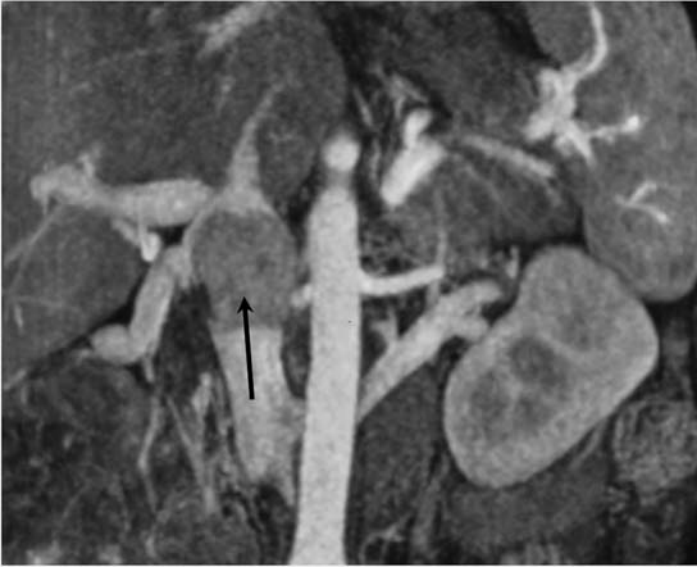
Coronal MR angiogram demonstrates a large thrombus in the inferior vena cava (arrow). Magnetic resonance imaging has been shown to be more accurate than CT in differentiating bland from tumor thrombus and for demonstration of venous wall invasion.
